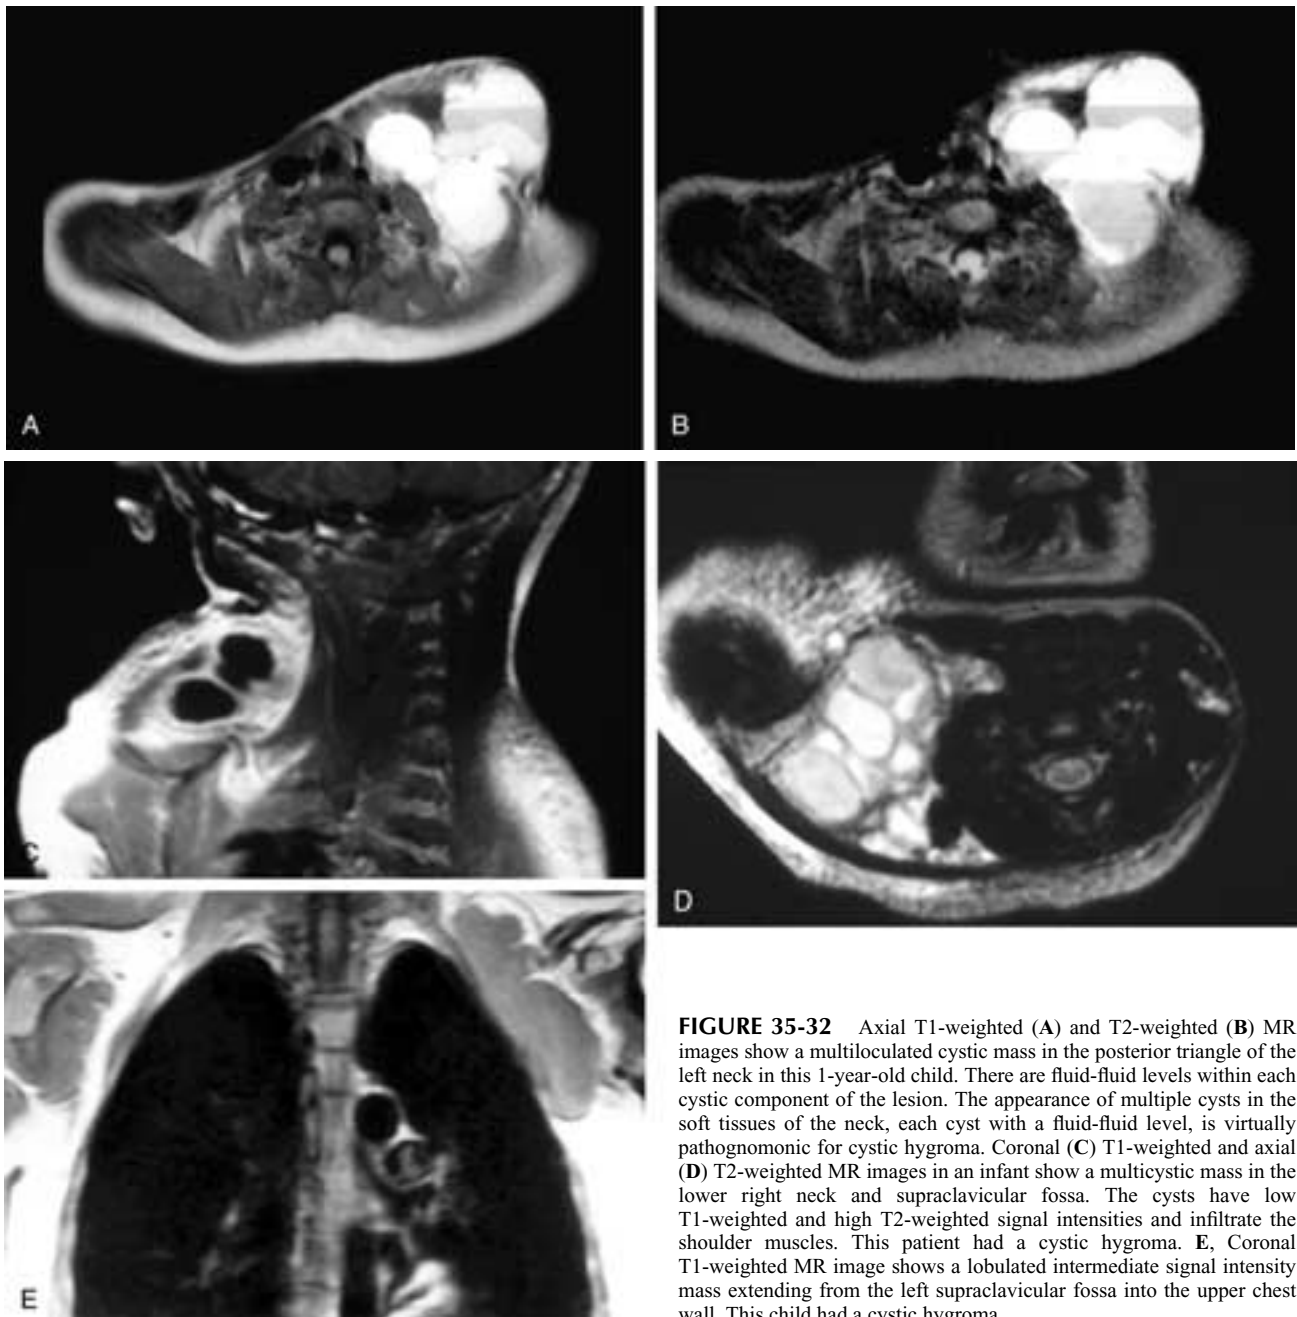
Axial T1-weighted (A) and T2-weighted (B) MR images show a multiloculated cystic mass in the posterior triangle of the left neck in this 1-year-old child. There are fluid-fluid levels within each cystic component of the lesion. The appearance of multiple cysts in the soft tissues of the neck, each cyst with a fluid-fluid level, is virtually pathognomonic for cystic hygroma. Coronal (C) T1-weighted and axial (D) T2-weighted MR images in an infant show a multicystic mass in the lower right neck and supraclavicular fossa. The cysts have low T1-weighted and high T2-weighted signal intensities and infiltrate the shoulder muscles. This patient had a cystic hygroma. E, Coronal T1-weighted MR image shows a lobulated intermediate signal intensity mass extending from the left supraclavicular fossa into the upper chest wall. This child had a cystic hygroma.
